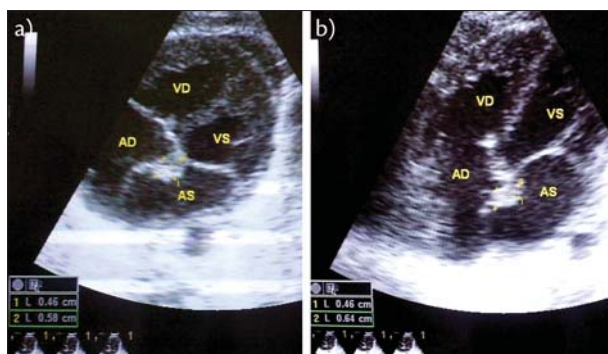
Neonatal echocardiogram (a) in subcostal four-chamber view and (b) long-axis four-chamber view; cardiac mass is visible in the left atrium, fixed to the primum atrial septum
